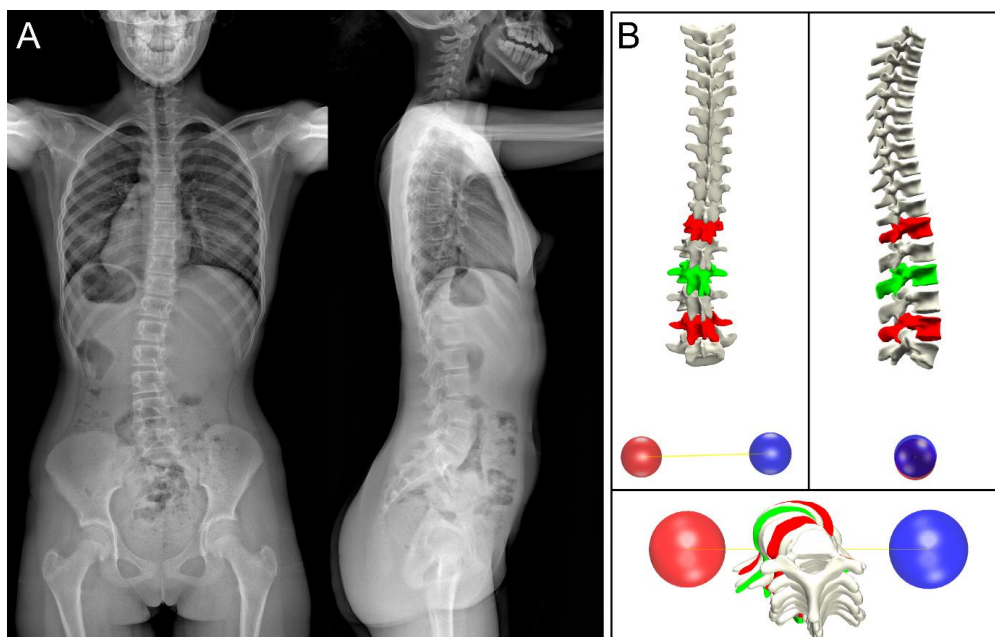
A: Bi-planar X-rays; B: patient-specific 3D reconstruction (apex is in green while junctional areas are in red; posterior, lateral and top views).
